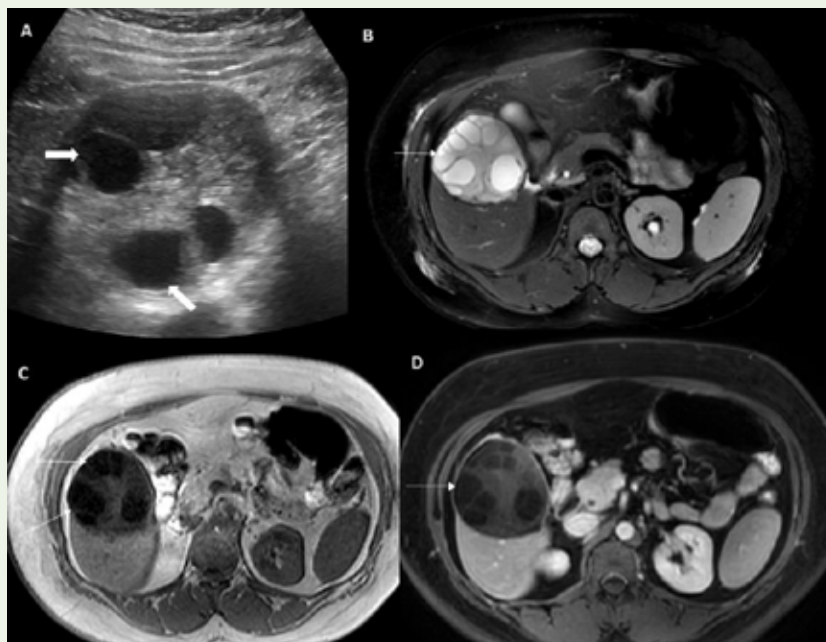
Case of a 37-year-old female with fever: Image A is an ultrasound image of the liver showing a well-defined hyperechoic lesion with few anechoic cystic lesions (marked by white block arrow), suggestive of daughter cysts (WHO stage CE-3B or Gharbi type II). Axial sections of T2-weighted (Image B), T1-weighted (Image C), and T1-weighted post-contrast (Image D) sequences of the same patient reveal a multivesicular, well-defined peripherally enhancing partially exophytic lesion with daughter cysts (marked by white line arrow).
